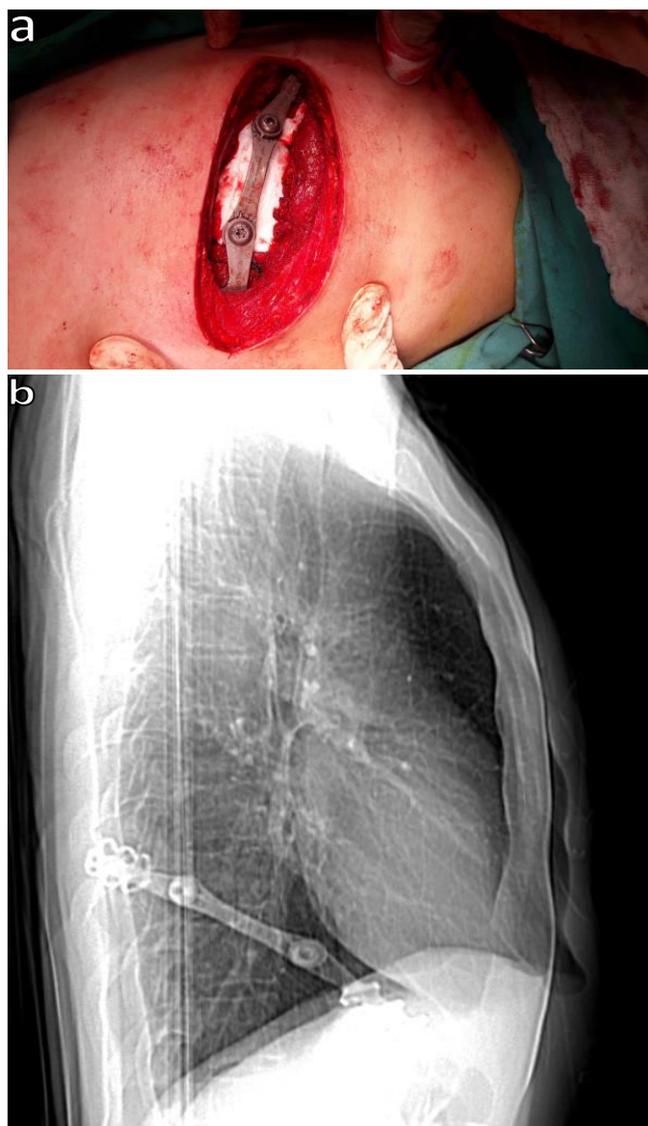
Reconstruction of the area with artificial ribs (a), postoperative lateral chest radiography (b)
